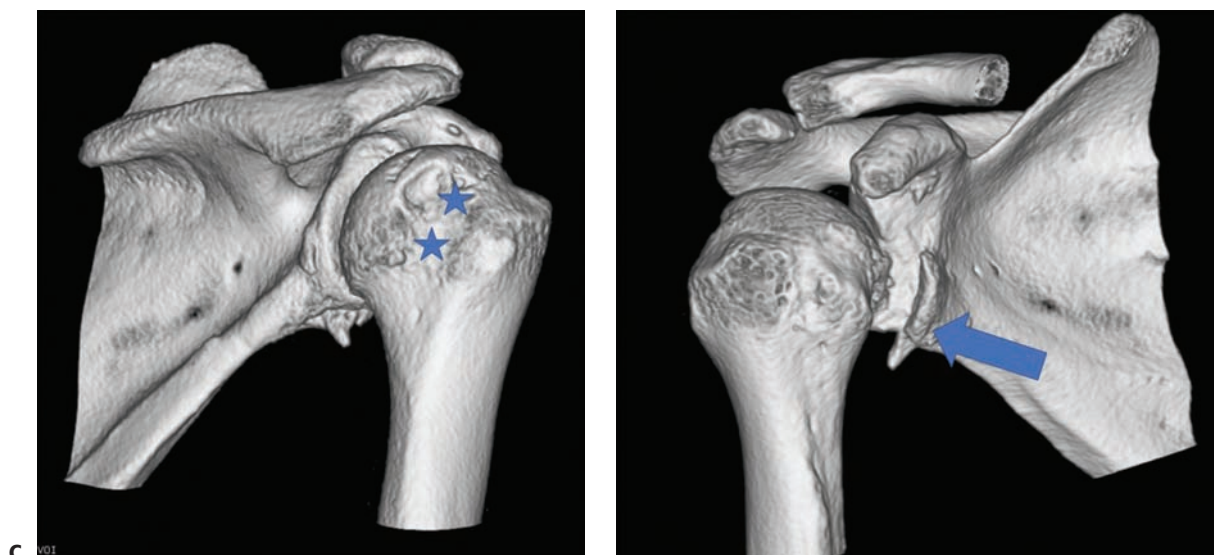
(Continued) C: CT with 3D reconstruction shows the Hills–Sachs lesions (stars). D: CT with 3D reconstruction shows the anterior bone Bankart lesions (arrow) and glenoid bone loss.
